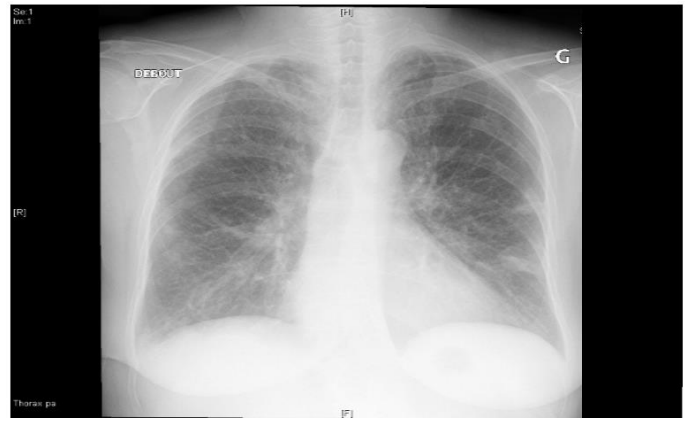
Initial chest X-ray showed bilateral interstitial infiltrates of the inferior lobes
